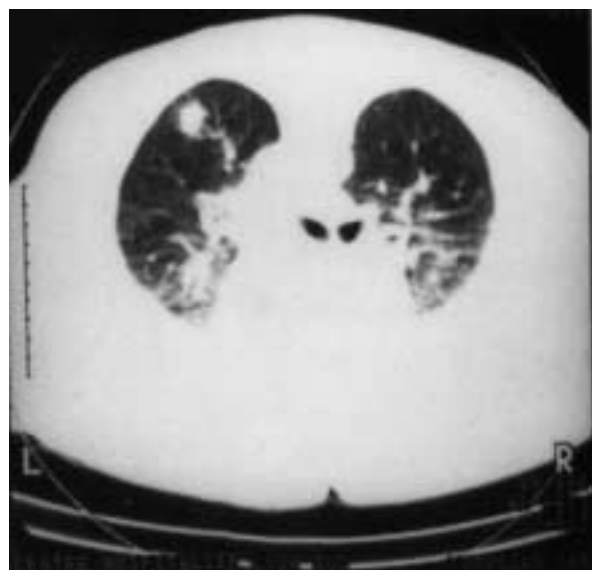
Chest computed tomography with irregular opacities in the upper lobes.
